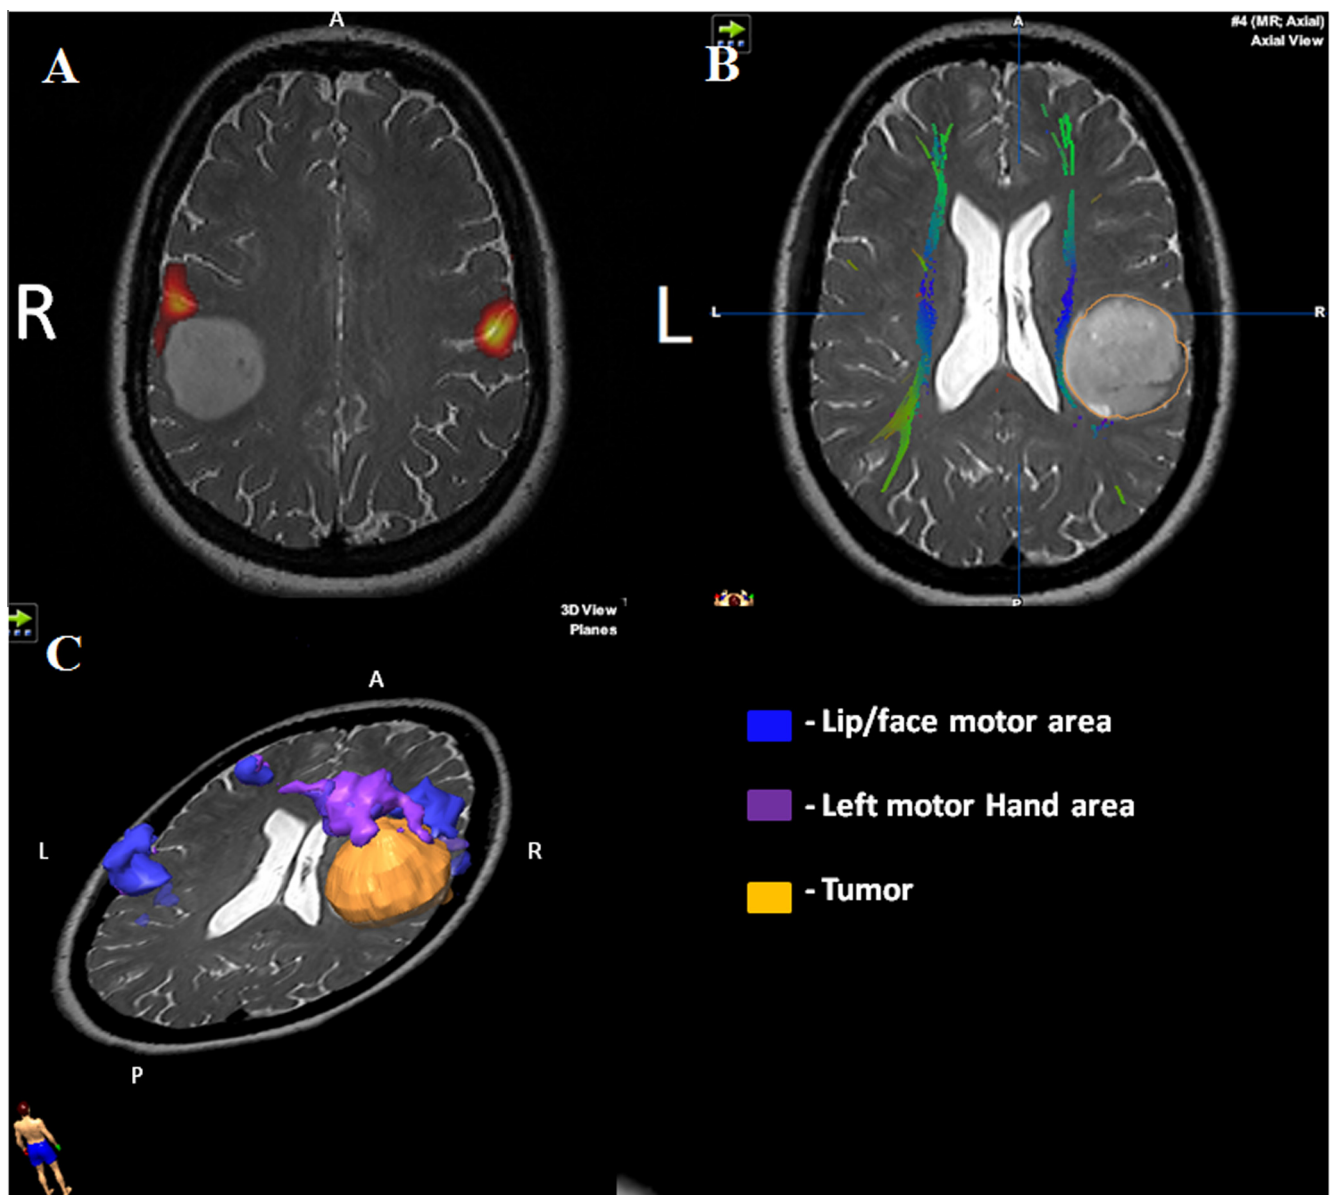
Preoperative axial functional MRI motor mapping in a 35-year-old left handed woman with a right hemisphere glioma. (A) Axial T2-weighted fast spin echo MRI. The red regions represent activated primary motor lip areas. (B) Axial gradient echo planar imaging and diffusion tensor imaging-based identification of the white matter tracts. An adjacent tumor (outlined in orange) compresses the tracts medially. (C) 3D reconstruction of the primary motor area (blue and purple) and adjacent glioma (yellow). A = anterior, L = left, P = posterior, R = right.
